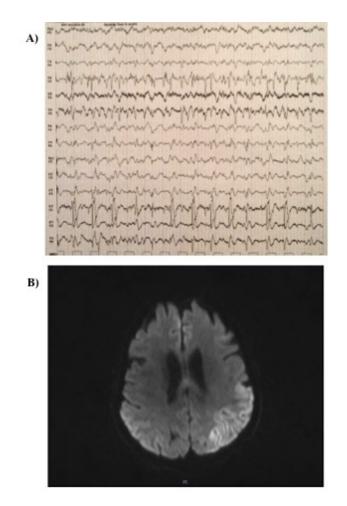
EEG and Brain MRI on admission. In A), EEG showing prominent bilateral parietal epileptic discharges. In B) DWI signal abnormalities bilaterally involving the parietal cortex.
